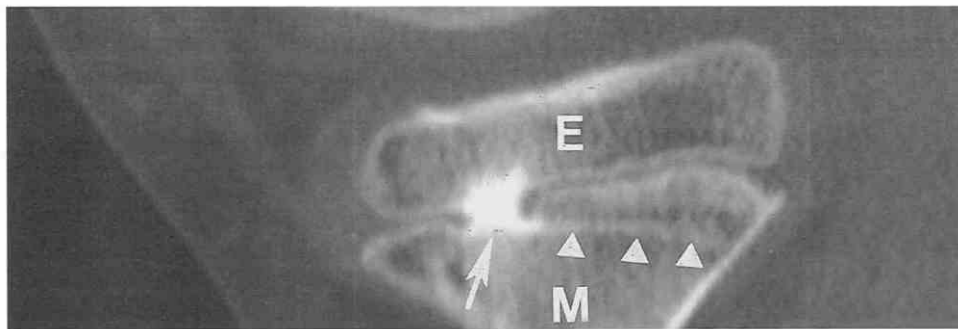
Post-traumatic growth arrest of the proximal tibia in an 11-year-old boy. A coronal CT reformat image from 1-mm collimation helical source images shows a focal bony bar (arrow) joining metaphysis (M) to epiphysis (E) across the growth plate. A growth line (arrowheads) is tethered by the bony bar. This bar was resected.
